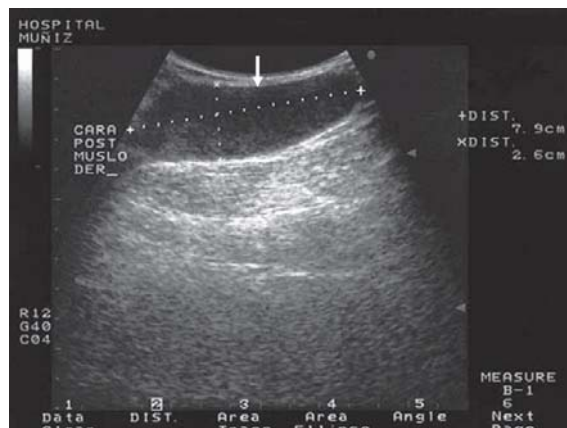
Ultrasound shows a hypoechoic liquid collection compatible with soft tissue abscess of the right thigh (arrow) of an HIV-infected patient with immune reconstitution inflammatory syndrome (IRIS).
